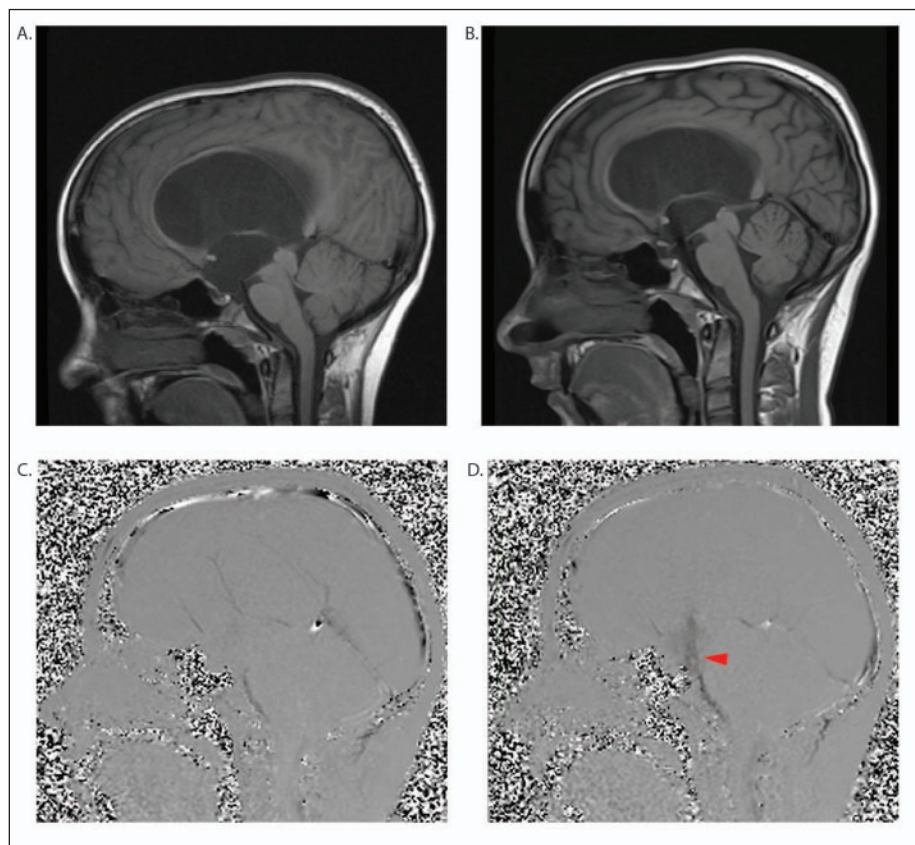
A) T1-weighted sagittal MRI of an 11 year-old male presenting with syncopal episodes in the setting of obstructive hydrocephalus secondary to tectal glioma. B) T1-weighted sagittal MRI of the same patient three years after ETV. Note the defect in the floor of the third ventricle. C) Pre-operative MR cine phase contrast image in the sagittal plane. D) Post-operative MR cine phase contrast image in the sagittal plane demonstrating CSF flow (red arrow) through the floor of the third ventricle.
